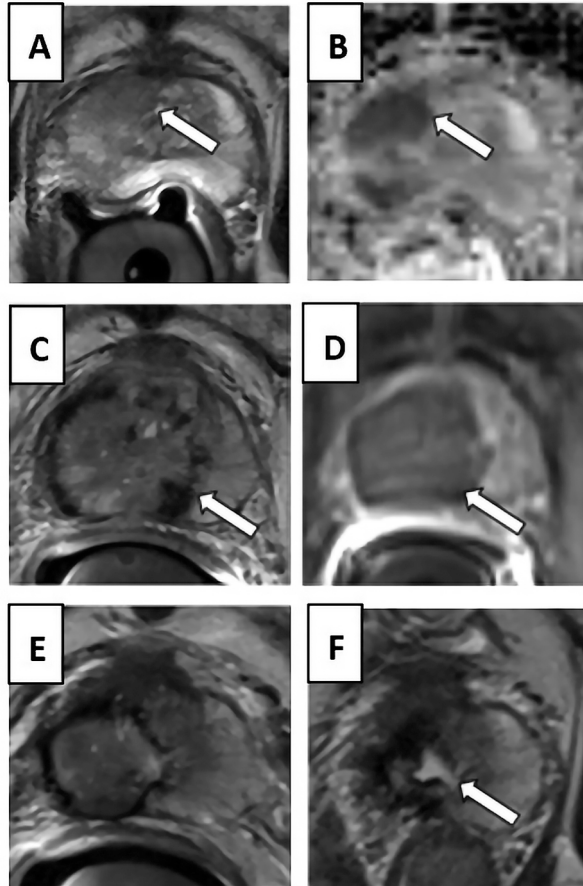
A patient example of post-HIFU MRI changes. In upper row baseline MRI images with a tumor focus with T2 hypointensity (A) and diffusion restriction on ADC map (B). In middle row a one-week post-HIFU MRI with heterogenous signal and edema of the ablation zone on T2W image (C) with low-signal peripheral hemosiderin deposition, and T1 fs contrast-enhanced image (D) showing non-perfused treatment area with surrounding rim of enhancement. In lower row T2W images at 6 months (E) and 18 months (F) post-HIFU showing gradual disappearance of the prostatic tissue from the treatment zone, T2 dark fibrosis, and TURP-like cavity formation (F). (Modified from (Ghafoor et al., 2020))
